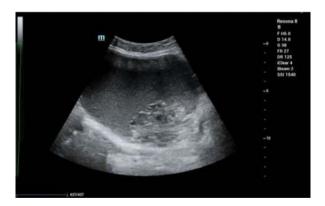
(a) Transabdominal ultrasound image of a unilocular mucinous cystadenoma. The uterus is outlined in orange; the tumor is circled in green; the mucinous deposit is circled in pink. (b) Transvaginal ultrasound image of the same case
